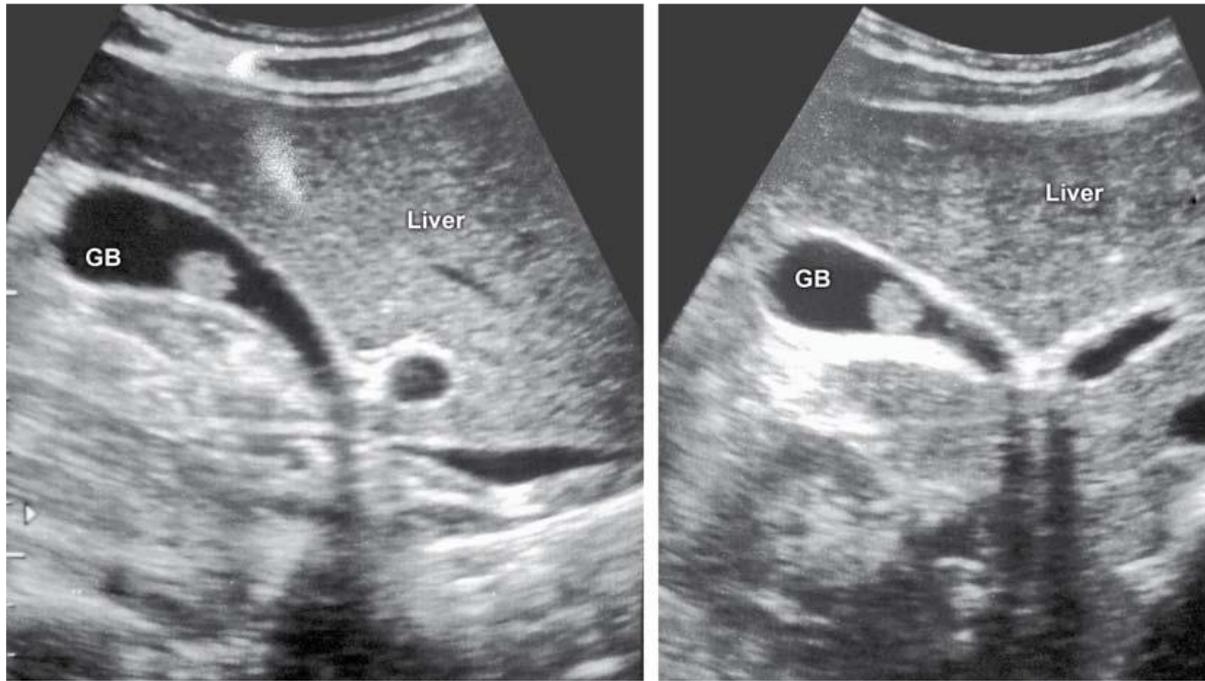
Ultrasound: gallbladder showing echogenic lesion. US should be done with change of position to find out movement of the lesion with posterior acoustic shadow to say it as gallstone. Otherwise it will be gallbladder polyp or sludge ball.
